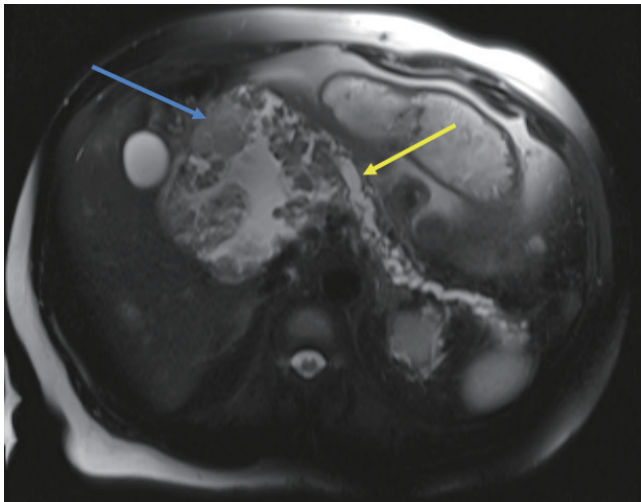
Axial, T2 weighted MRI of a 60-year-old male demonstrates diffuse pancreatic ductal dilation measuring up to 9 mm (yellow arrow) to the level of a large pancreatic cystic lesion in the pancreatic head measuring up to 11.8 cm with solid components measuring up to 4.2 cm (blue arrow). Both of these are considered concerning features. The patient underwent a Whipple procedure based on these findings, and pathology revealed intraductal oncocytic papillary neoplasm without invasive carcinoma.
